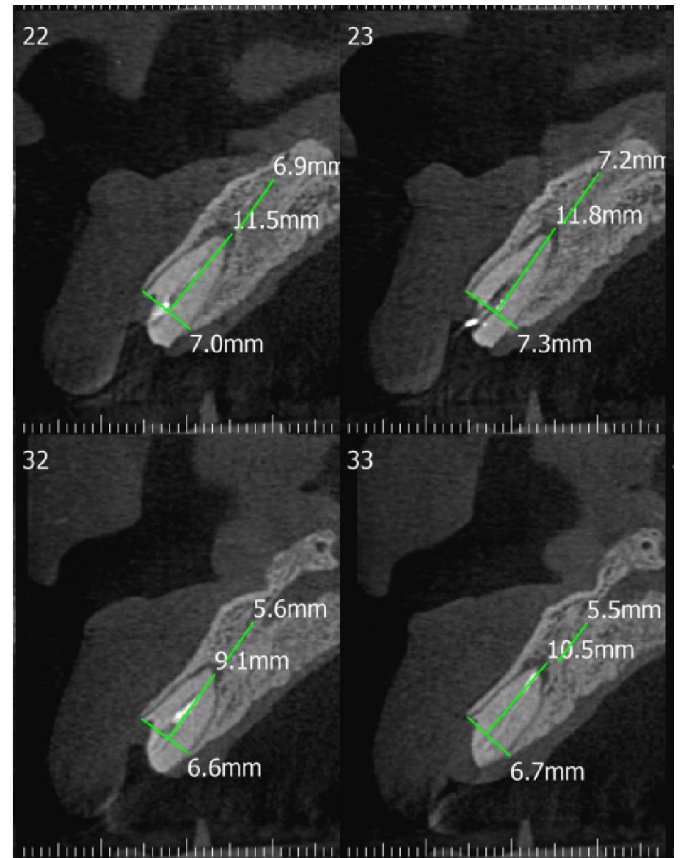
CBCT revealing remaining root stumps with intact buccal and palatal cortical plate
